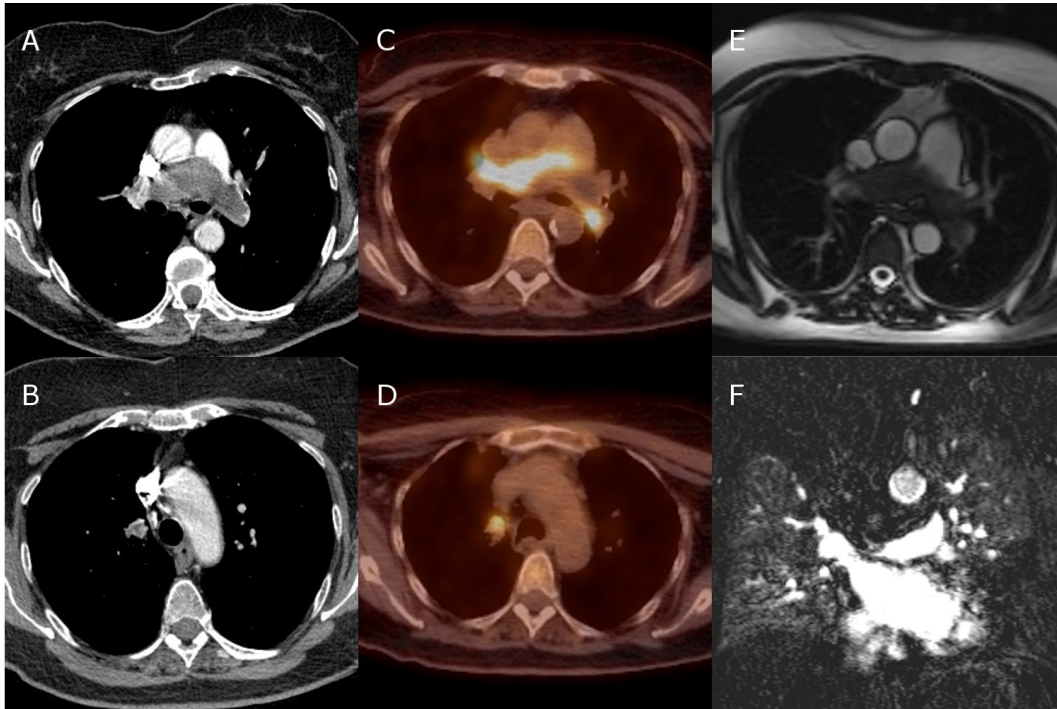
A selection of images from a patient with a pulmonary artery angiosarcoma. There is a soft tissue density filling defect on the CTPA within the proximal pulmonary artery, extending into both left and right pulmonary arteries (A), and also extending into the right upper lobe (B). This is hot on the PET-CT scan (C+D). SSFP cine cardiac MRI demonstrates the mass as an isodense filling defect in the pulmonary arteries (E) and there is a perfusion defect in the right upper lobe (F).
